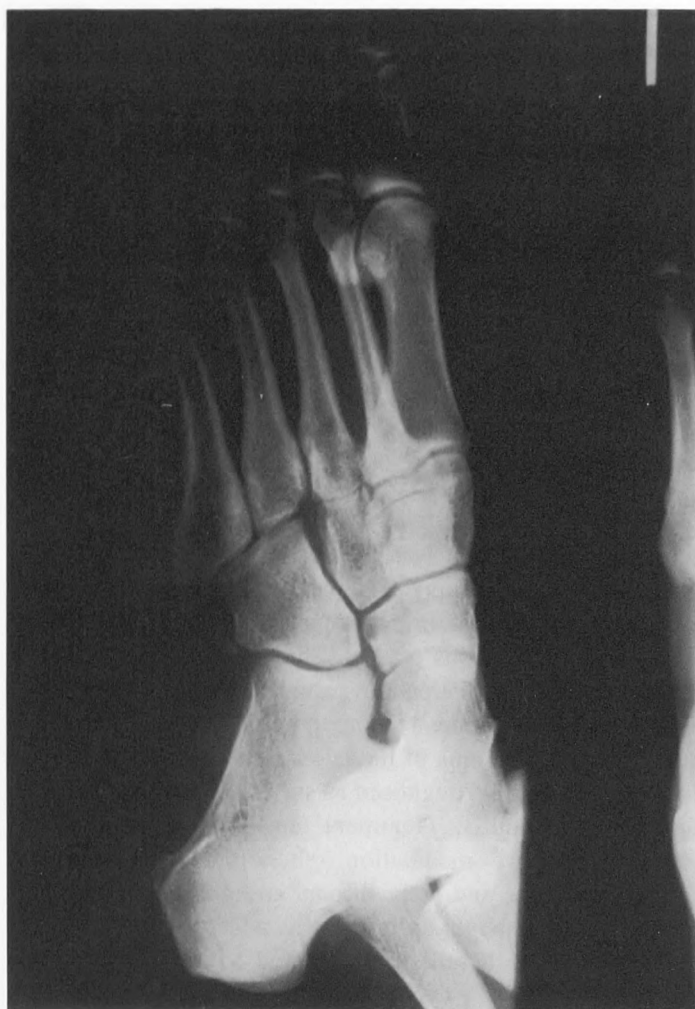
X-ray of left foot.
